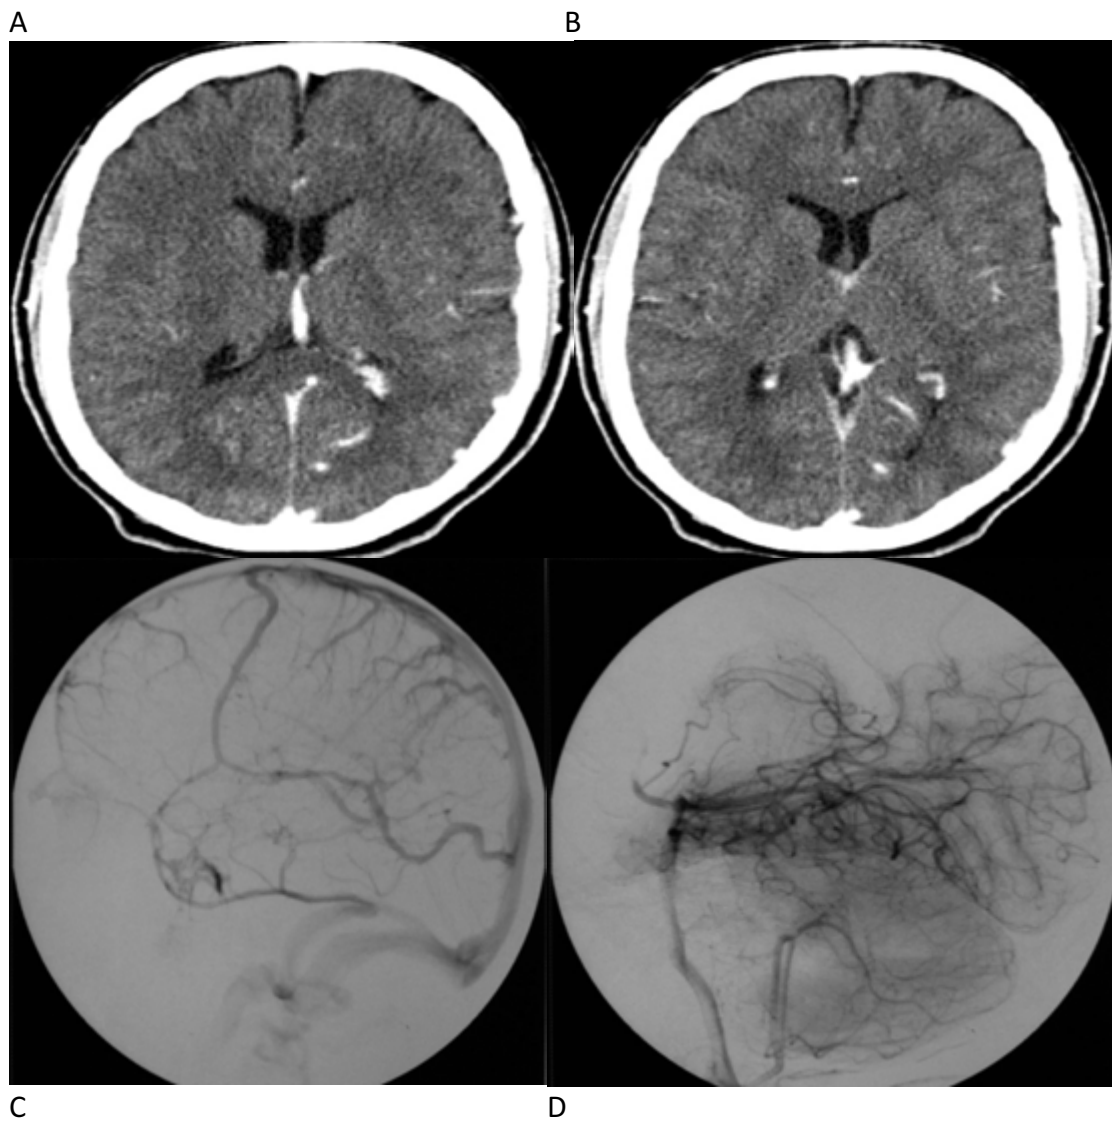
A 16 year old patient presented with sudden severe headache. A and B CT brain (with gadolinium, axial) no haemorrhage could be identified, a dilated vein was noted related to the left lateral ventricle. C and D Angiography showed a deep to superficial type DVA draining the left lateral ventricle region, two prominent posterior communicating thalamoperforating vessels are seen.
